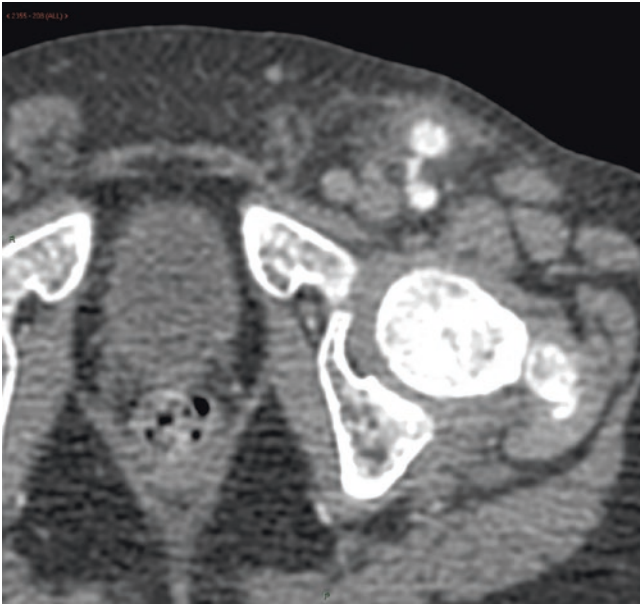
Arterial phase CT scan confirmed focal pseudoaneurysm sac communicating with the left common femoral artery at the puncture site
